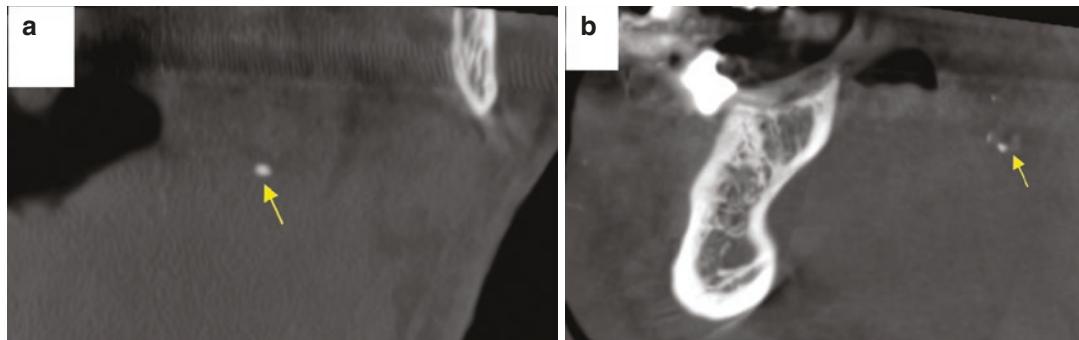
CBCT images show smaller multiple tonsilloliths (yellow arrows)
